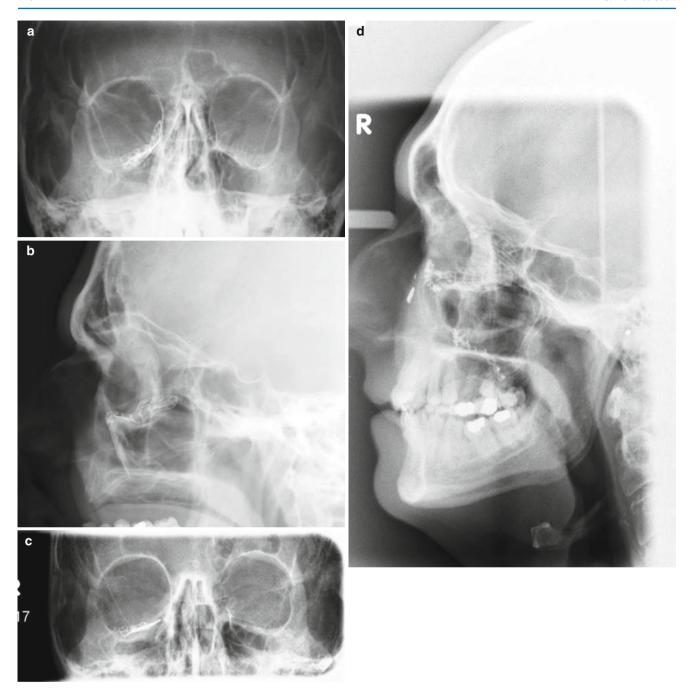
(a-d) Postoperative imaging is recommended with these plates. Precise placement is very technique sensitive. In these cases, plain films have been taken
